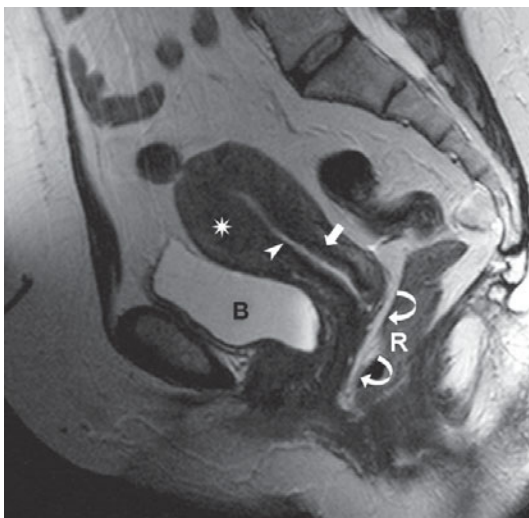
Magnetic resonance. Uterus. T2-weighted sagittal image. The hyperintense signal identifies the endometrial cavity (arrowhead), and the hypointense signal the junctional zone (arrow). The asterisk indicates the myometrium. The curved arrows indicate the rectovaginal septum. B, urinary bladder; R, rectum
